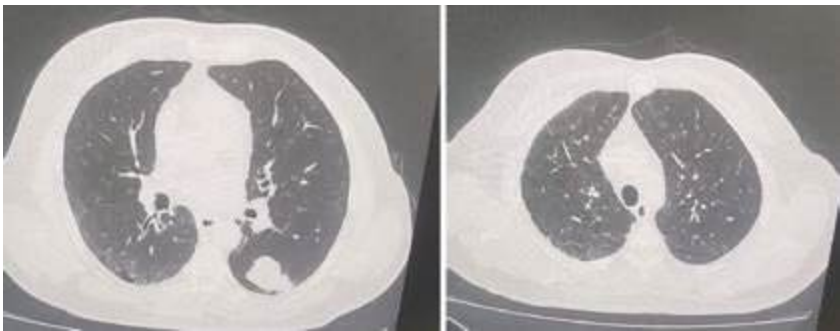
Image 4. Axial HRCT image (lung window setting) showing a dense pulmonary neoplasm in the left lower lobe in the presence of mild centrilobular and paraseptal emphysematous changes.
